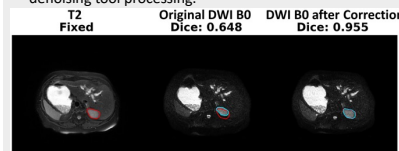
Processing results with DWI-Agent's distortion correction tool. The red contour outlines the ROI on T2, and the cyan contour outlines the ROI on DWI.
